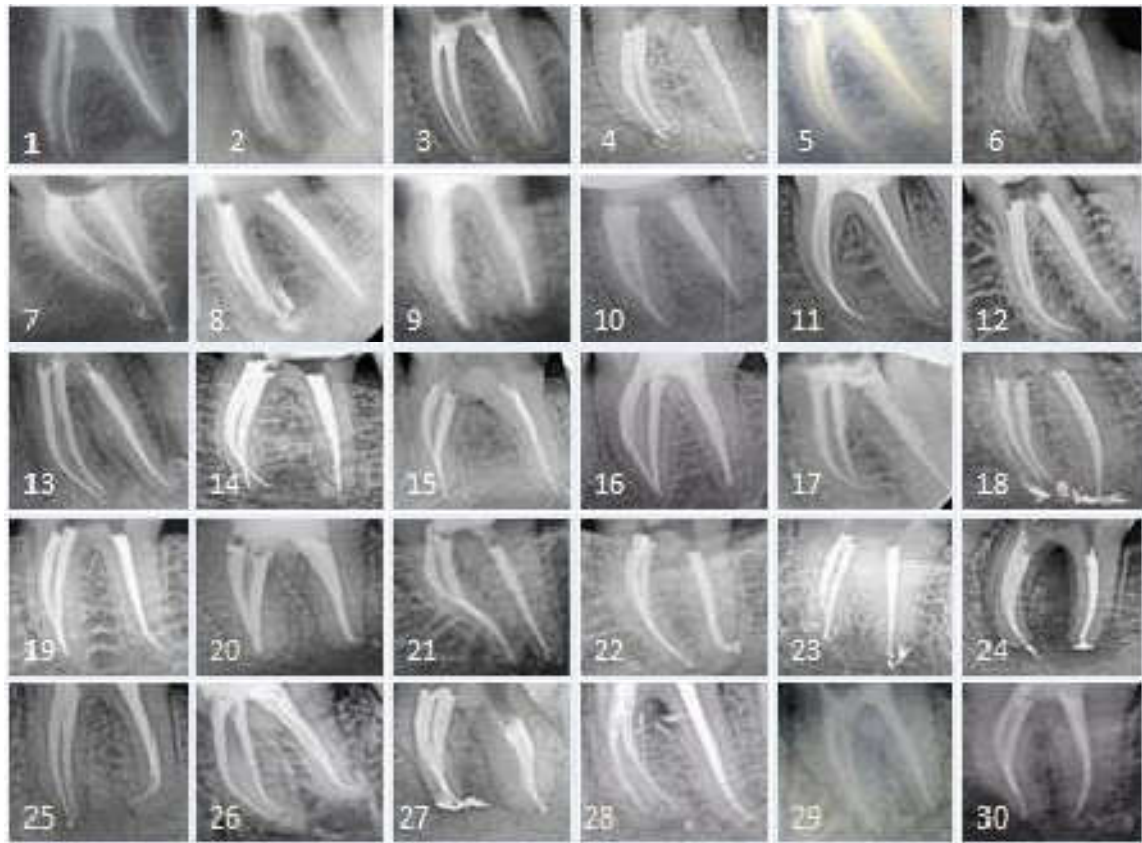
SET 1; Radiographs represent ante-mortem labelled from (1-30)
